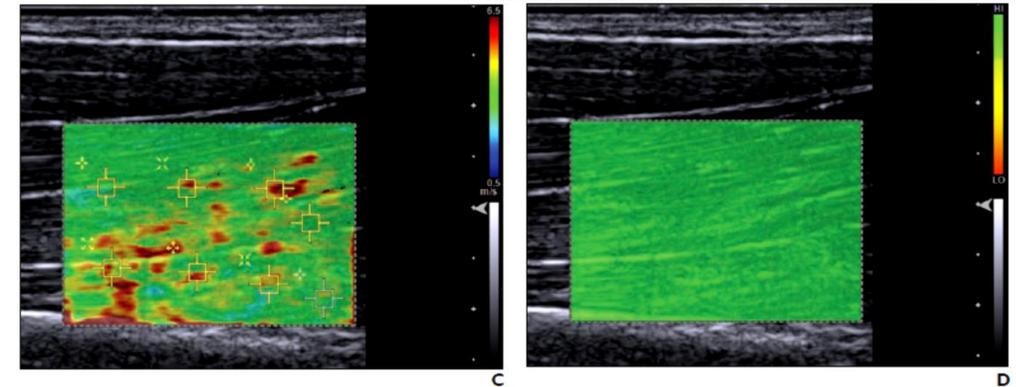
(continued)—Color-coded shear-wave ultrasound elastography maps of 40-year-old male volunteer (male volunteer 5 in Tables 1 and 2). Maps were obtained using Virtual Touch Tissue Imaging Quantification (VTIQ, Siemens Healthcare) software.
